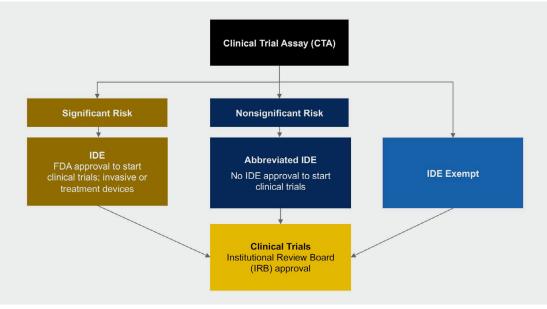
Risk assessment and regulatory requirement for a CTA
